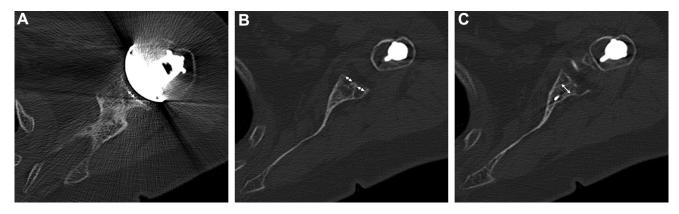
Computed tomography scan evaluation of a 79-year-old woman, 109 months after anatomic total shoulder arthroplasty of the left shoulder. Measurement of the superior (A) and inferior peripheral pegs (B), and measurement of the central peg (C) (*white arrows*) determined the grading of radiolucency. A width <5 mm for the peripheral pegs and a width <9 mm of the central peg were measured. In this case, no signs of loosening were seen with bone ingrowth in all compartments of the central peg.
